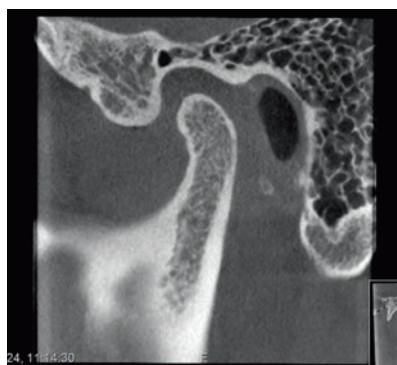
Left jaw and ear cells imaged by CBCT.
